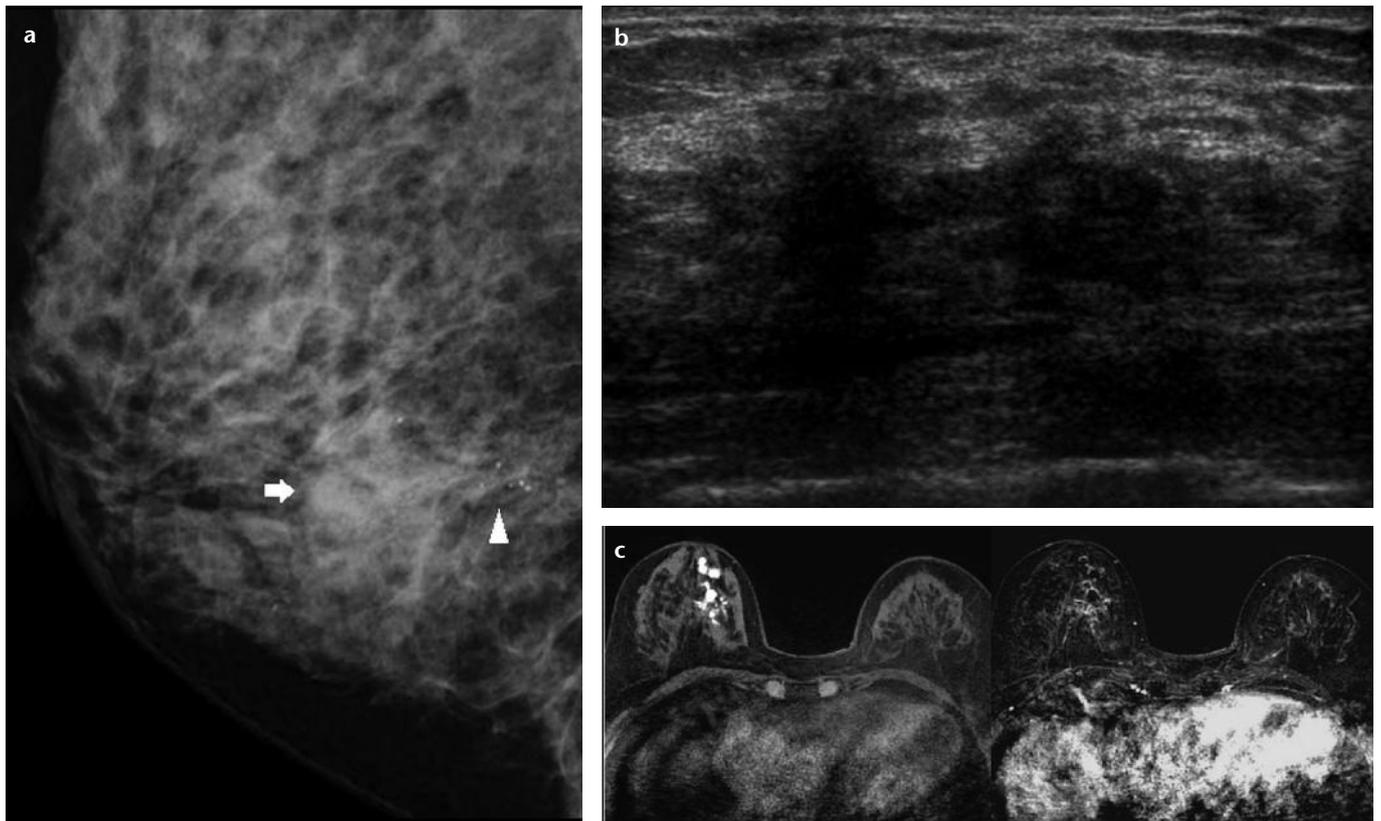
a–c. A patient recalled for assessment of a screen-detected abnormality in the right breast. The mammography in mediolateral-oblique view (a) shows an asymmetric density (arrow) associated with loosely clustered calcifications (arrowhead) in the right lower breast. US (b) shows a poorly defined hypoechoic area from the 3 o'clock to 6 o'clock position in the right breast. MRI (c) performed for further evaluation shows the lesions as lobulated, high-signal nodules in a ductal distribution on the axial vibrant precontrast phase (left-sided image). Subtracted image (right side) of the fifth minute after contrast injection shows mild patchy enhancement in the affected area. MR-guided vacuum-assisted biopsy of the abnormal area yielded an intraductal papilloma. The patient declined surgical excision biopsy.
